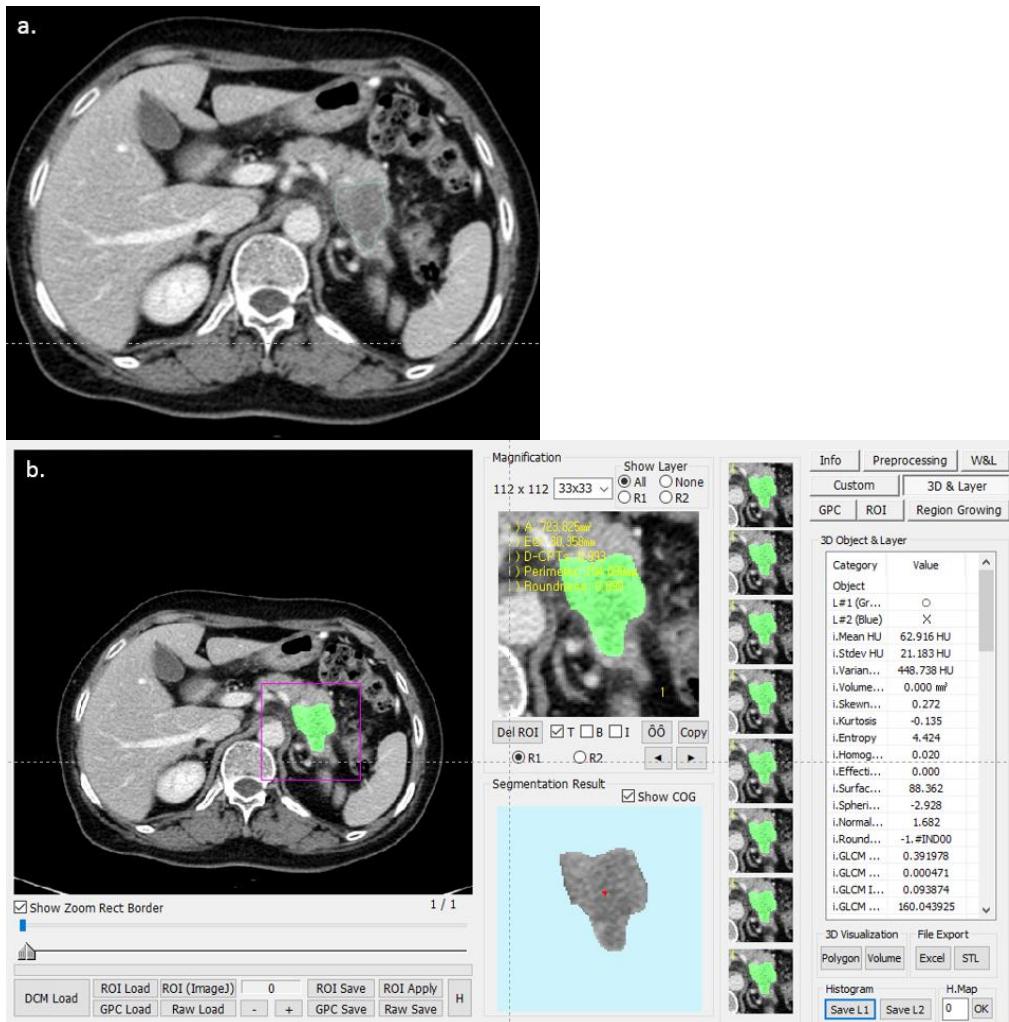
CT texture analysis software program on 2D. The outlining of pancreatic adenocarcinoma was manually conducted, prior to texture analysis (a). Subsequently segmentation was performed with consensus manner, by using computer-based in-house texture analysis software program and texture features of the nodules were automatically extracted and calculated (b).
